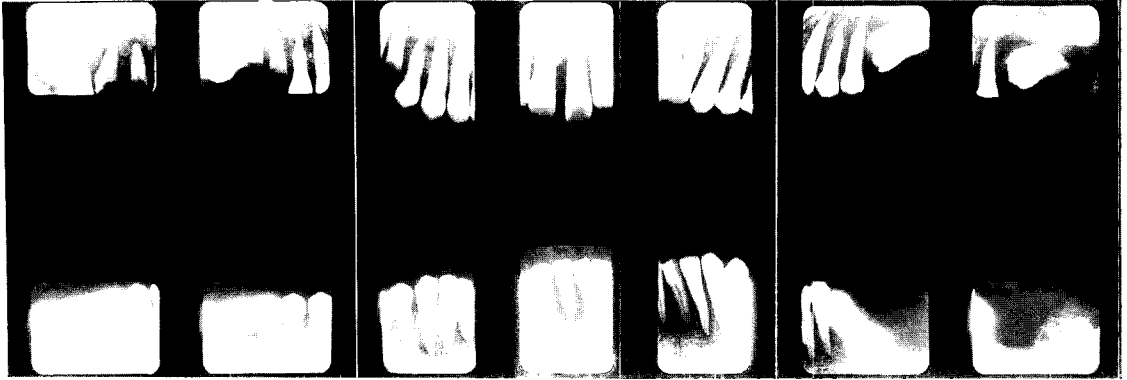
Periapical radiographs demonstrating loss of alveolar lamina dura on entire dentition.
